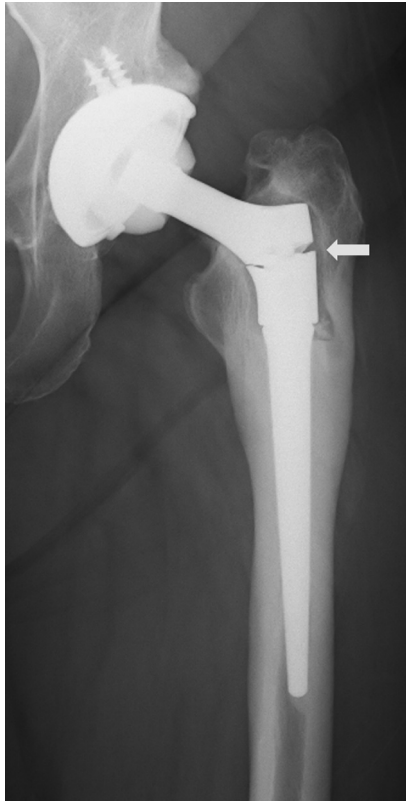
Radiographic examination of the patient's left total hip arthroplasty at 3 years and 8 months postoperatively showing a fracture of the modular neck component.
